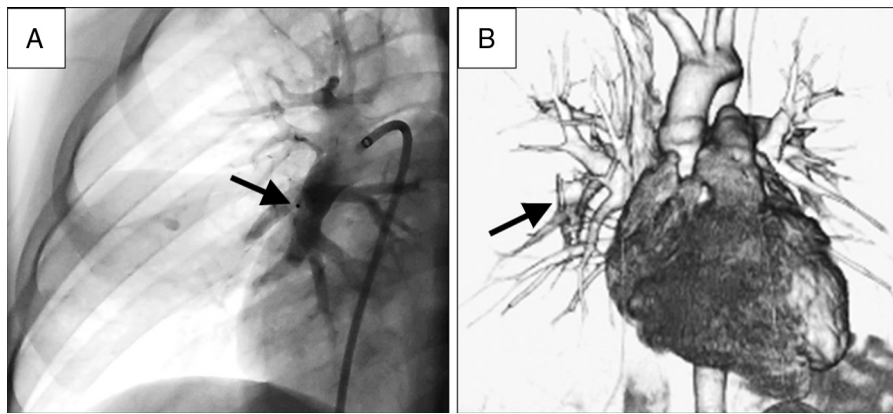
(A) Post-procedure angiography. Look at the permeability of the pulmonary vessels distal to the device (arrow). (B) Control CT scan (6th month). 3D reconstruction showing occlusion of pulmonary artery pseudoaneurysm (arrow).
